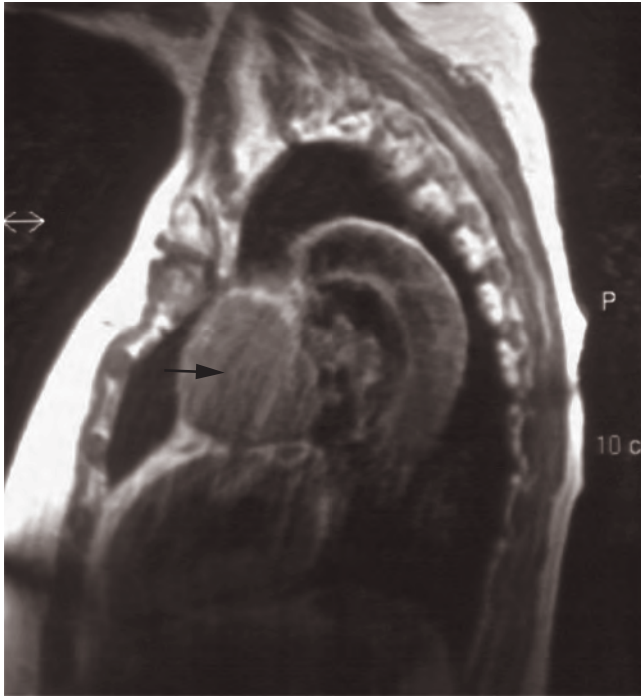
Large anterior mediastinal thymoma in an 80-year-old patient with mild generalized MG (MRI T2W).
